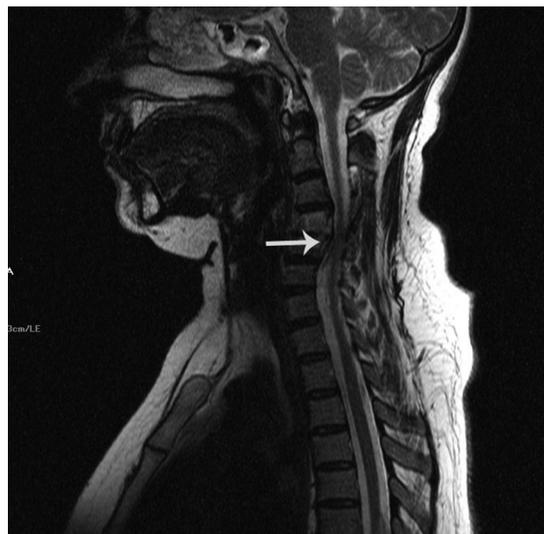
Sagittal T2 weighted image demonstrated the progression of inflammatory enhancement in the vertebral corpus and disruption of the disk posteriorly, with near partial resolution of the soft tissue thickening (arrow) in the epidural space on control MR imaging after therapy.
